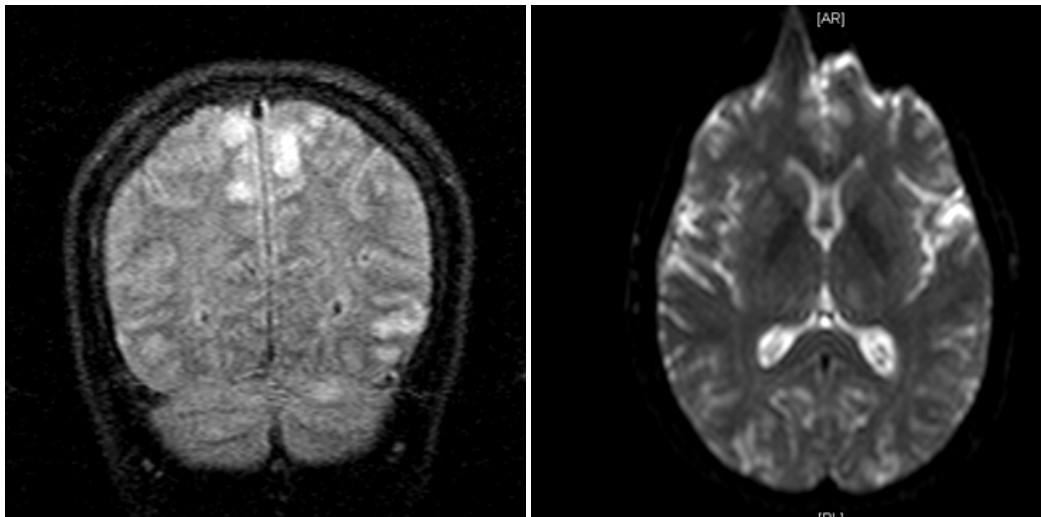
(a and b) Brain MRI showed interval development of non-enhancing bi-hemispheric and bilateral cerebellar hyper intense foci likely reflective of posterior reversible encephalopathy syndrome.
